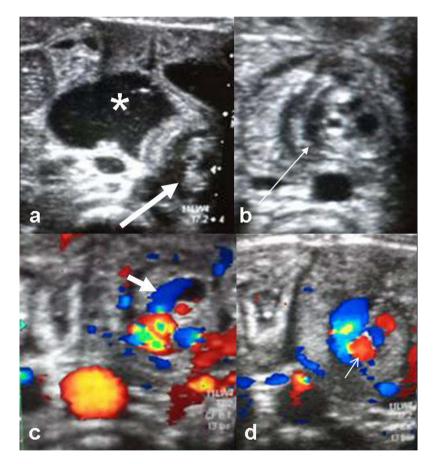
Serial US images in a 17 days old neonate with bilious vomiting. (a) US image of dilated duodenum (*) with adjacent volvulus mass (long thick arrow). (b) US image of volvulus mass (Long thin arrow). (c) Color Doppler image showing the winding SMV (Short thick arrow). (d) Color Doppler image depicting the central site of SMA (short thin arrow).
